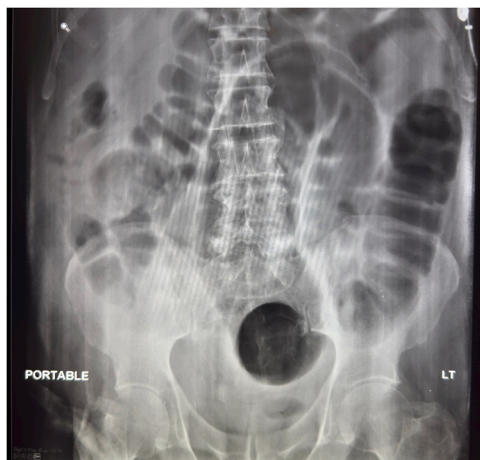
XRAY abdomen frontal view.
